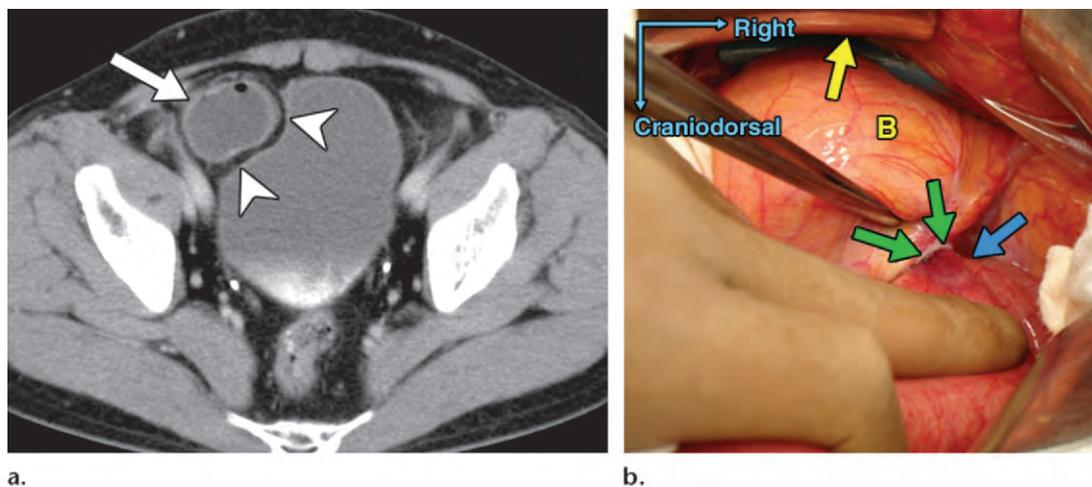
Internal supravesical hernia in a 74-year-old man with a 1-day history of right lower abdominal pain. (a) Axial contrast-enhanced CT image shows incarcerated intestine with a saclike appearance (arrow) that compresses the anterior wall (arrowheads) of the urinary bladder on the right. (b) Intraoperative photograph (superoanterior view) shows incarceration of the ileum (blue arrow) into the right supravesical fossa (green arrows). Approximately 7 cm of intestine was infarcted and was resected. The defect was approximately 2 cm in diameter. The hernia sac was resected, and the hernia orifice was closed with sutures. B = urinary bladder, yellow arrow = pubis.
